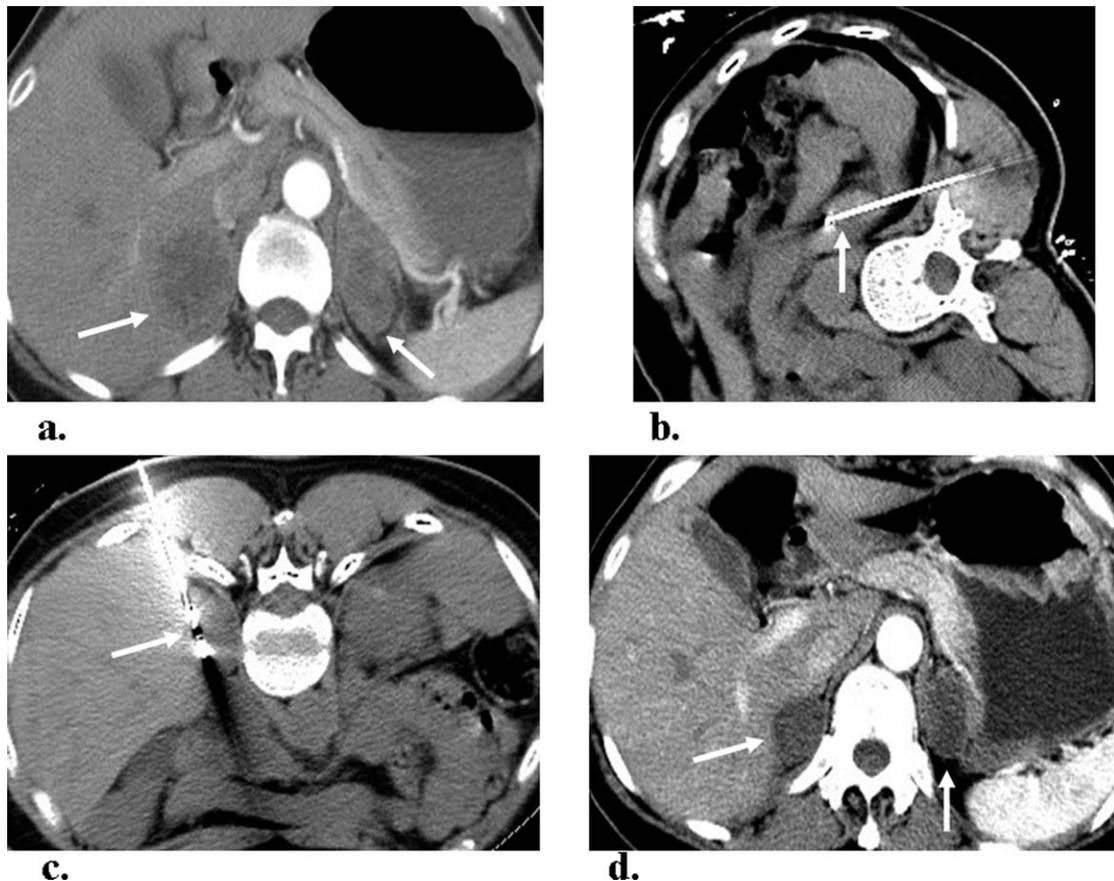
A 54-year-old female patient with isolated bilateral adrenal metastasis from large cell lung carcinoma with tumors measuring 4.1×3.9 cm (right-side) and 3.6×2.5 cm (left-side). (a) Abdominal transverse enhanced CT scanning shows bilateral adrenal metastasis. (b) In the right supine position, microwave ablation is performed on the left adrenal metastatic tumor. (c) In the prone position, microwave ablation is performed on the right adrenal metastatic tumor (arrow indicating the microwave ablation antenna). (d) Enhanced CT scanning shows no tumor enhancement 6 months after the operation.
